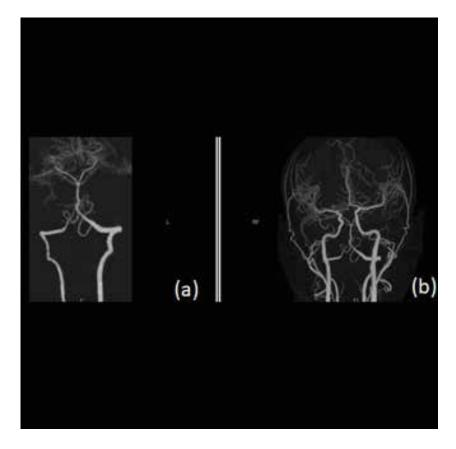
CT angiogram showing mild narrowing of bilateral vertebral arteries more on the right side (a) and a patent anterior circulation with normal caliber of both internal carotids, anterior and middle cerebral arteries (b).
